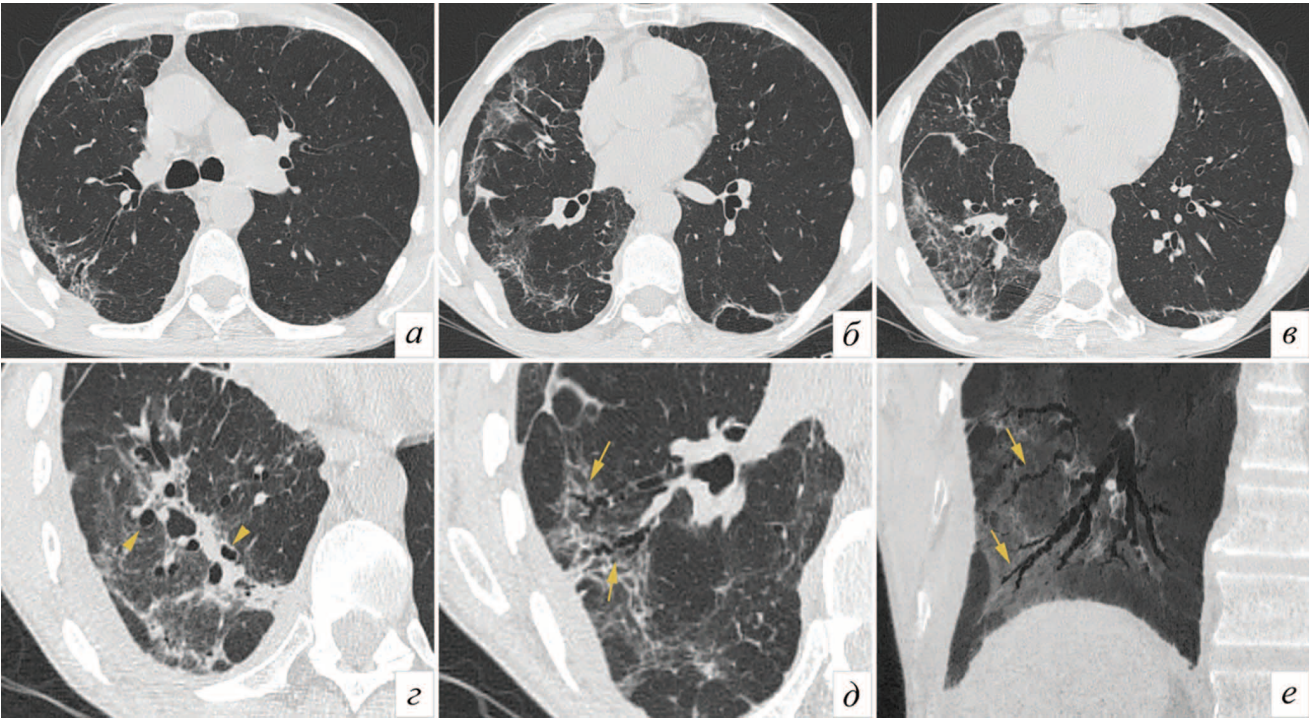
Patient K., 73 years old. 4 weeks after discharge for COVID-19 (PCR+). Thoracic CT scans in the axial projection (a-c), enlarged image fragments (d, e) and MinIP reformation (e). Against the background of low-intensity areas of “ground glass” (more on the right), there are stringy hardenings that deform the lung tissue and pleura. Cylindrical (arrow heads) and varicose (arrows) broncho- and bronchiolectasis are also visualized
